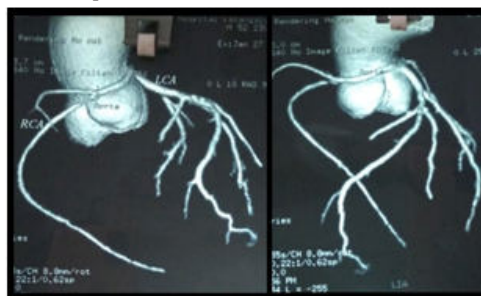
CT Coronary angiogram
